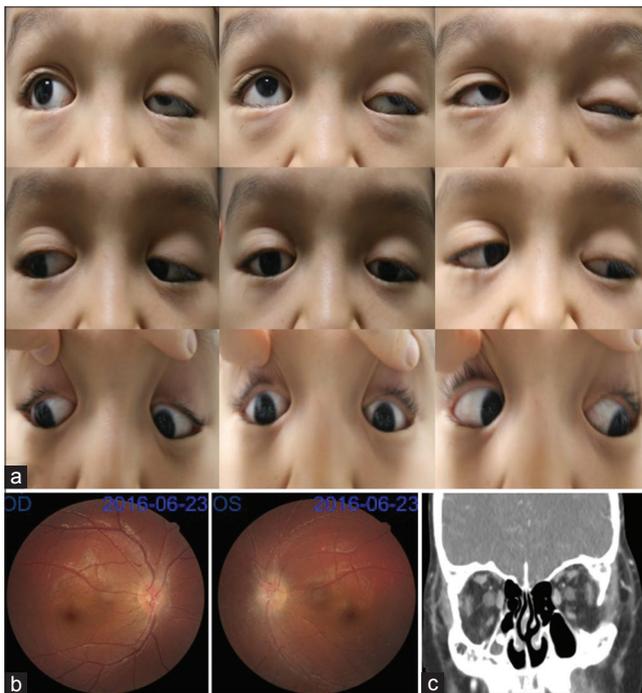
Gaze photography, fundus photography, and computerized tomography (CT) scan of the orbits for case 2. (a) Versions showing a left hypotropia and V-pattern exotropia with bilateral inferior oblique overaction. (b) Fundus photographs showing mild excyclotorsion in the left eye. (c) CT scan showing dysmorphic orbits and excyclorotation of the right orbit
